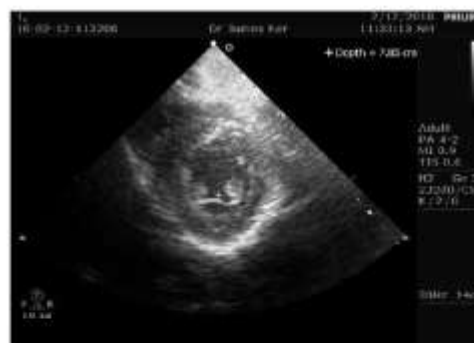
Parasternal, short-axis view during systole.
